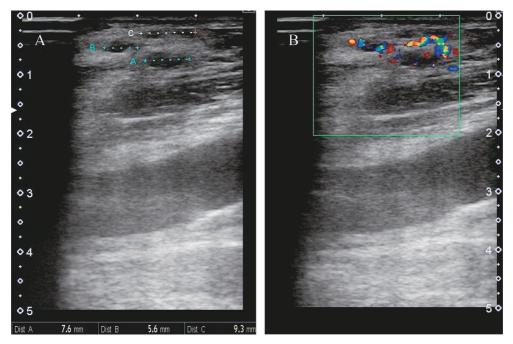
Ultrasonography in left forearm.
